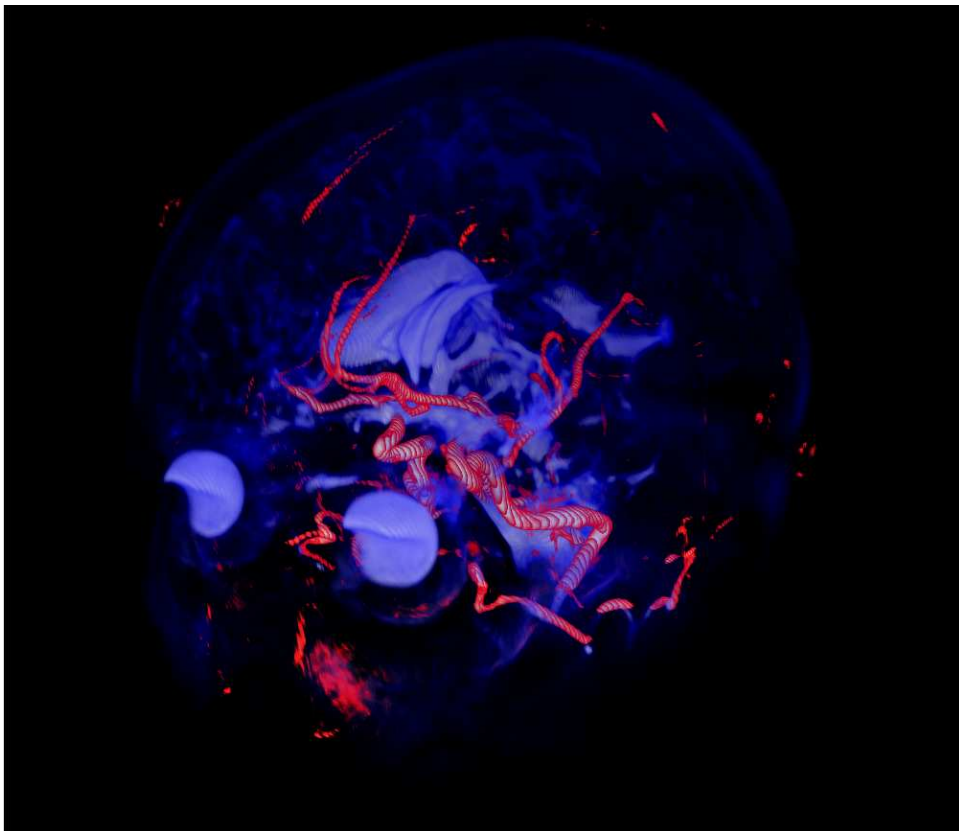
Volume renderings of MRI T2 (*blue*) and MRA (*red*)
